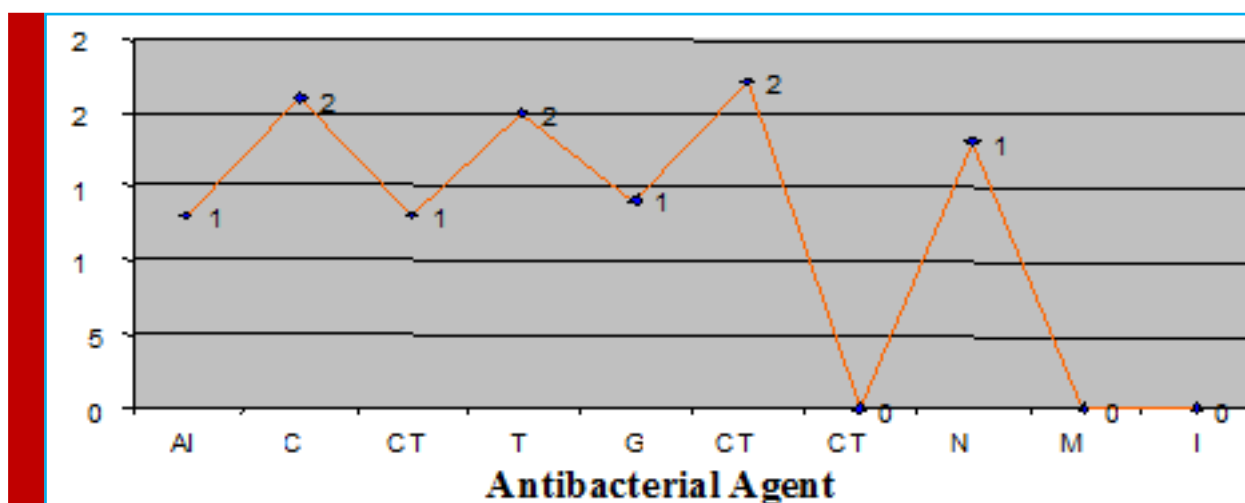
Antibacterial Activity of *Salmonella paratyphi* A. AI - Amikacin, C - Chloramphenicol, CT - Co-trimoxazole, T - Tetracycline, G - Gentamycin, CTR - Ceftriaxome, NX - Norfloxacin, MR - Meropenem, I - Imipenem
